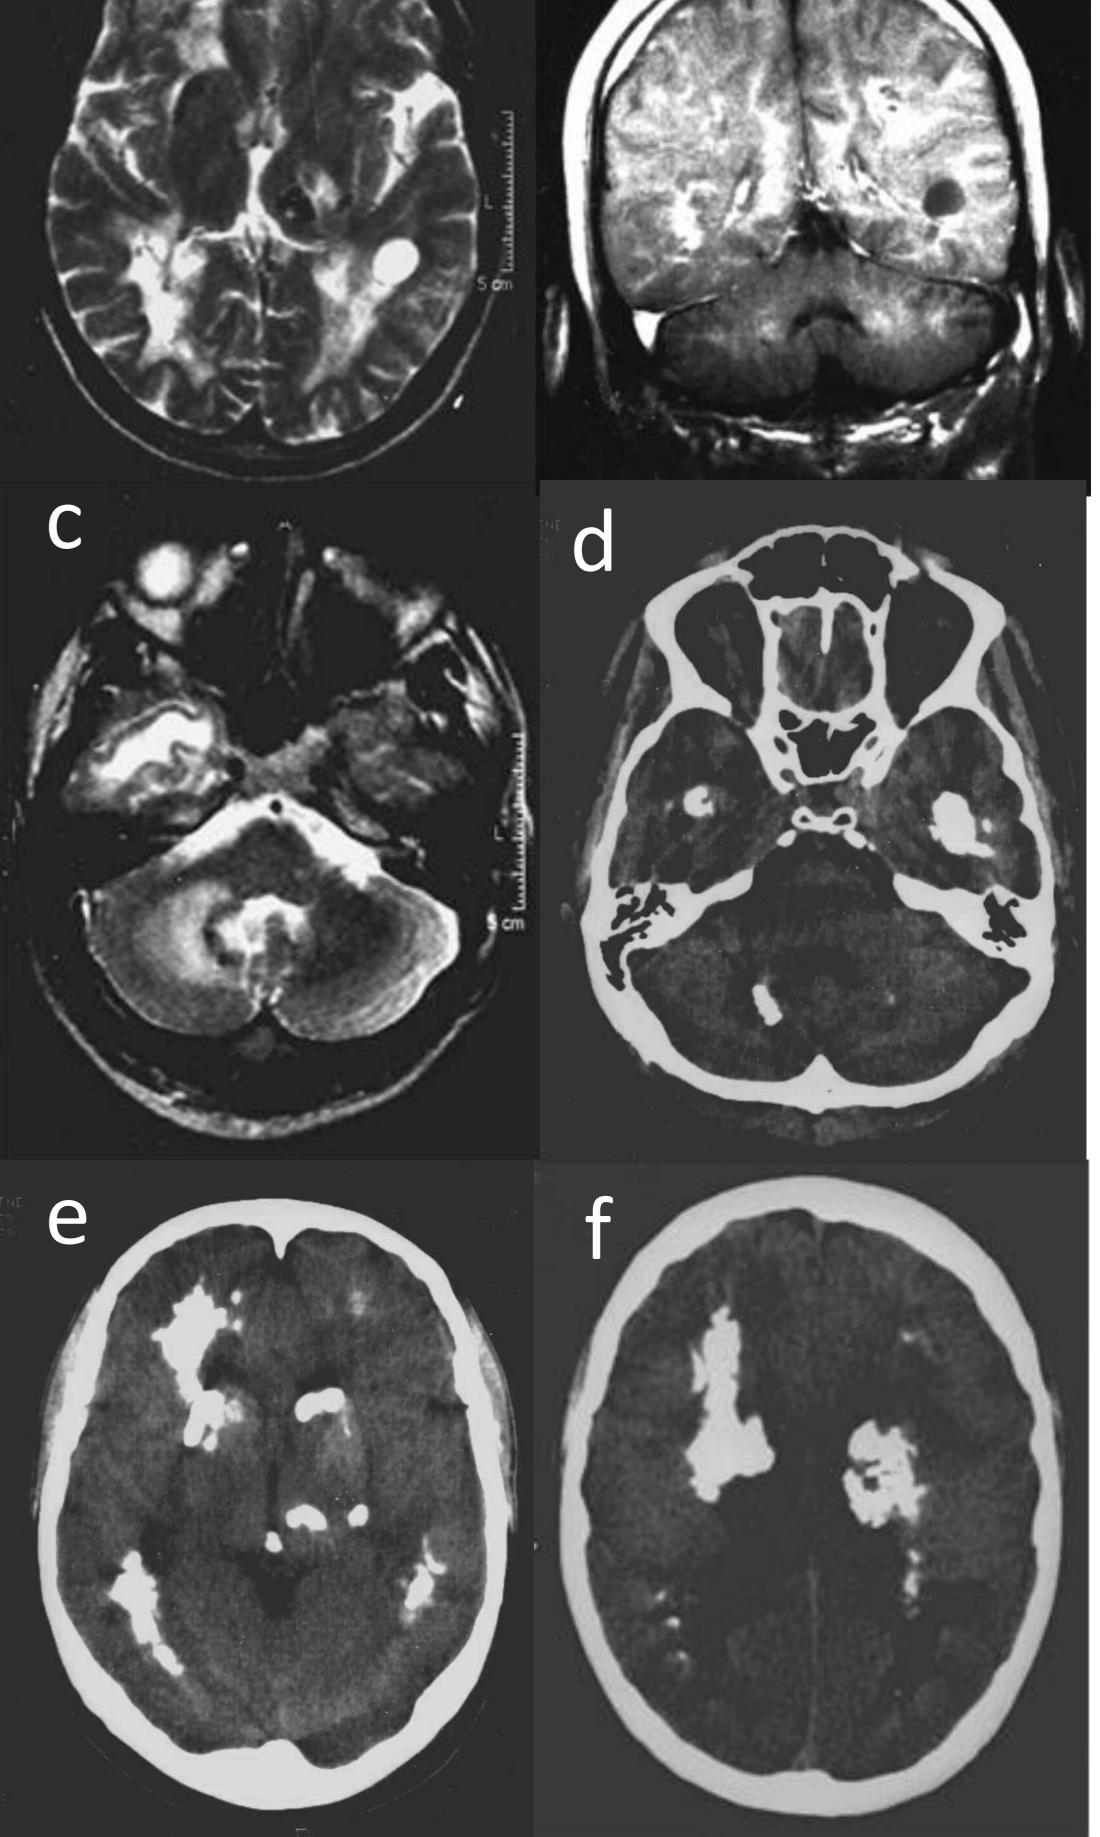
a-c) Axial T1-weighted brain MRI; b) Coronal fluid-attenuated inversion recovery (FLAIR) brain MRI; d-f) non consecutive brain CT scans
